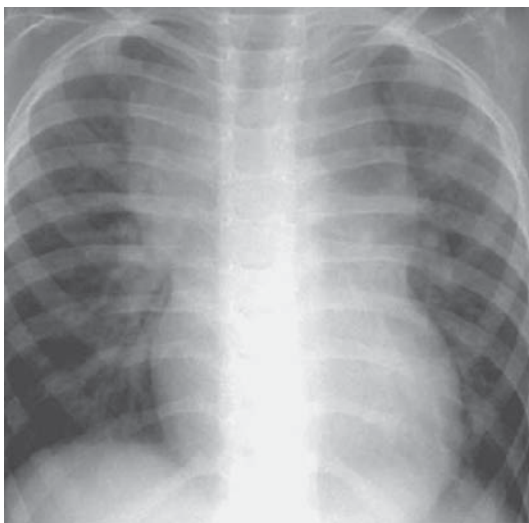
Chest X-ray in total anomalous venous return showing figure of eight or snowman appearance. Head of snowman is made of superior mediastinal shadow formed by SVC on right side, vertical vein on left side and left brachiocephalic vein superiorly. Body of snowman is the heart. Sometime termed snowman in snowstorm in which snowstorm refers pulmonary plethora.
